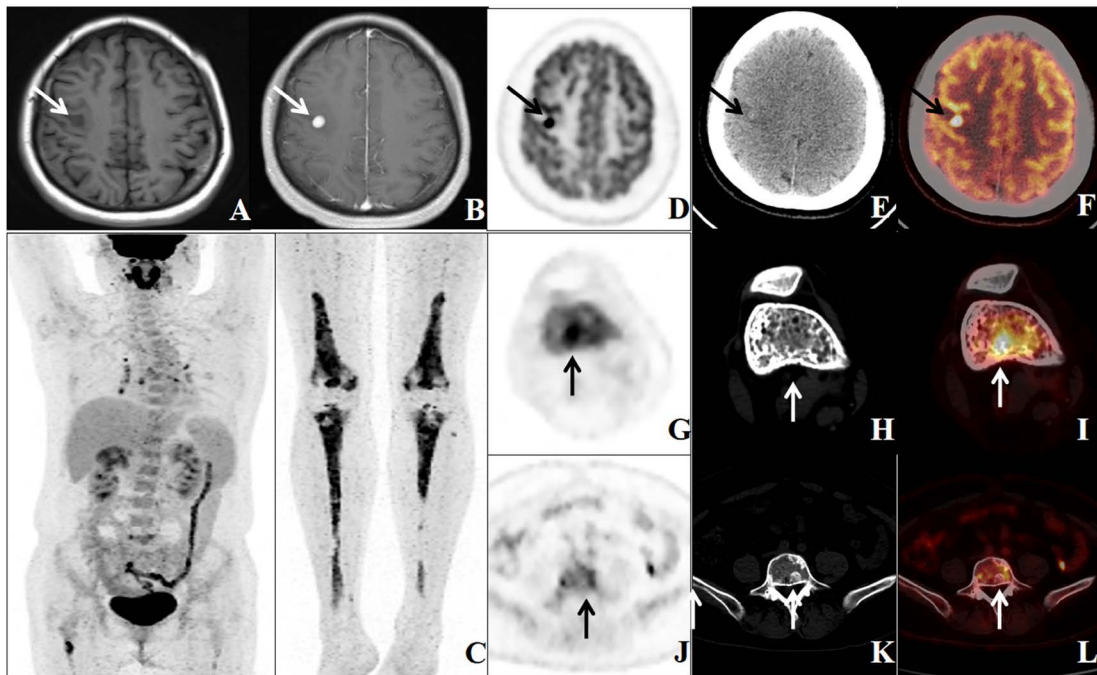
MRI and PET/CT image. (A-B, arrow): The signal nodule in the right frontal lobe showed low T1-weighted signal and obvious enhancement. (C): The MIP showed bilateral and symmetrical increased uptake in the diaphysis of the femur and tibia. (D, PET image; E, CT image; F, fused PET/CT image): The axial views of the brain showed the known brain nodule with a size of 1.0cm×0.8cm and increased activity (SUVmax 41.3). (G, PET image; H, CT image; I, fused PET/CT image): Axial views of the right femur showed increased FDG uptake (SUVmax 11.9). (J, PET image; K, CT image; L, fused PET/CT image): Transaxial images showed the involvement of the fifth lumbar vertebra with intense FDG uptake (SUVmax 5.5).
